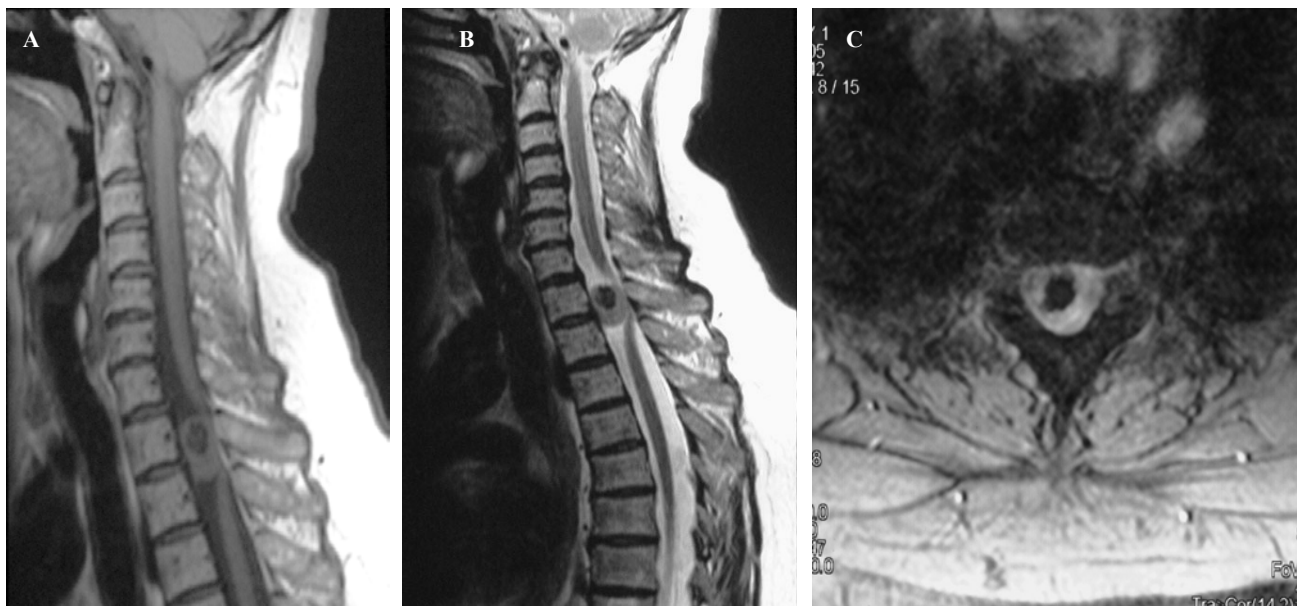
Magnetic resonance Imaging of the patient, A: T1W1 saggital view, B: T2W1 saggital view, and C: T2W1 axial view showing intradural extramedullary tumor.
